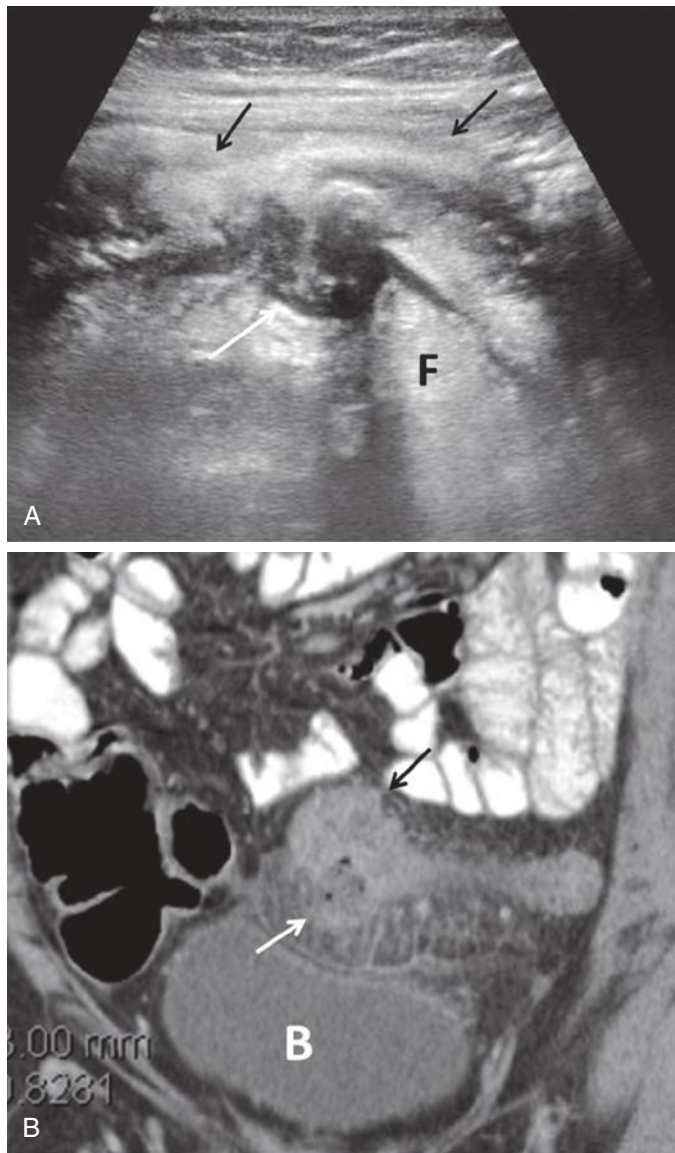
Acute sigmoid diverticulitis in a patient with left pelvic pain. A, Evaluation of the left lower quadrant with a linear ultrasound transducer shows thickened sigmoid colon (*black arrows*). There is a focal outpouching with fluid and debris (*white arrow*) representing the inflamed diverticulum. The adjacent inflamed pericolonic fat (F) is hyper-echoic. B, Coronal reformatted image from contrast-enhanced computed tomography demonstrates inflamed diverticulum (*white arrow*), with bowel wall thickening (*black arrow*) and stranding in the adjacent pelvic fat consistent with inflammation. B, urinary bladder.
